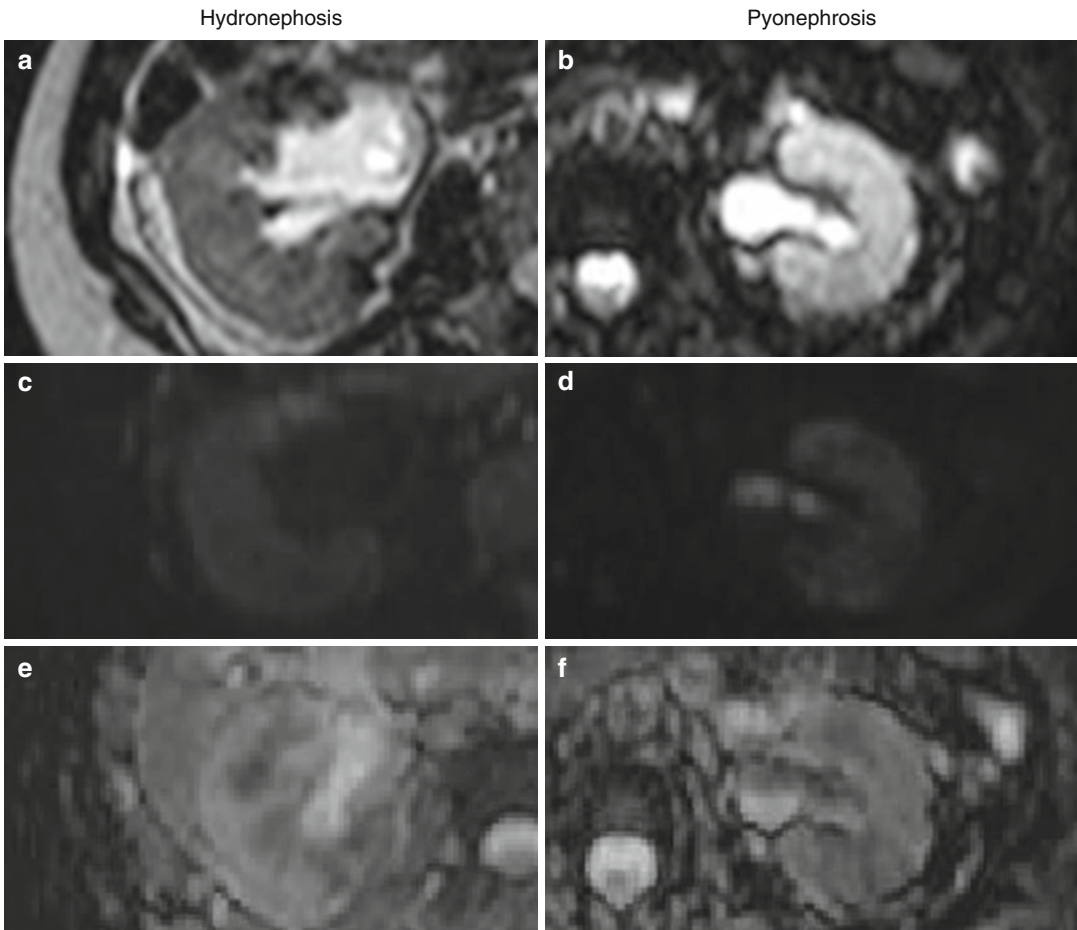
T2-weighted (a, b) and DWI comparison with $b=1,000$ (c, d), with relative ADC map $b=0-1,000$ (e, f). Subtle signal inhomogeneity in the context of the renal pelvis in T2-weighted images (a, b); homogeneous hypointensity of the pelvis in DWI sequences in a case of hydronephrosis (c), sign of high diffusibility, in sharp contrast to the findings in the case of pyonephrosis, where
